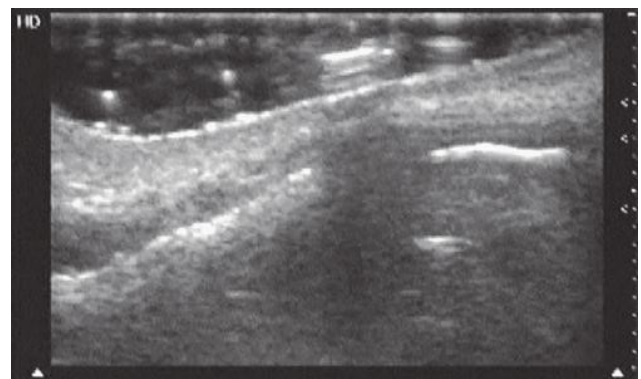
US still image of nasal fracture demonstrating cortical disruption. A large gap is seen between bone fragments. [Reproduced with permission from Ma OJ, Mateer JR, Blaivas M: *Emergency Ultrasound*, 2nd ed. © 2008, McGraw-Hill, New York.]
